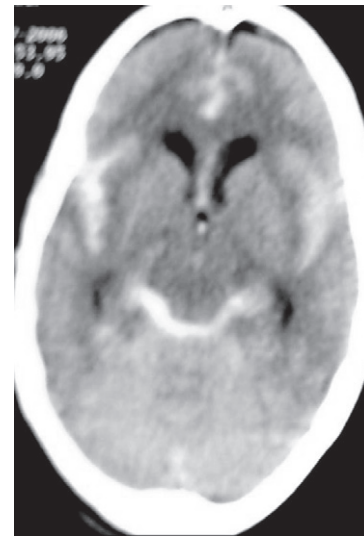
Non-contrast CT head showing blood in all the basal cisterns
